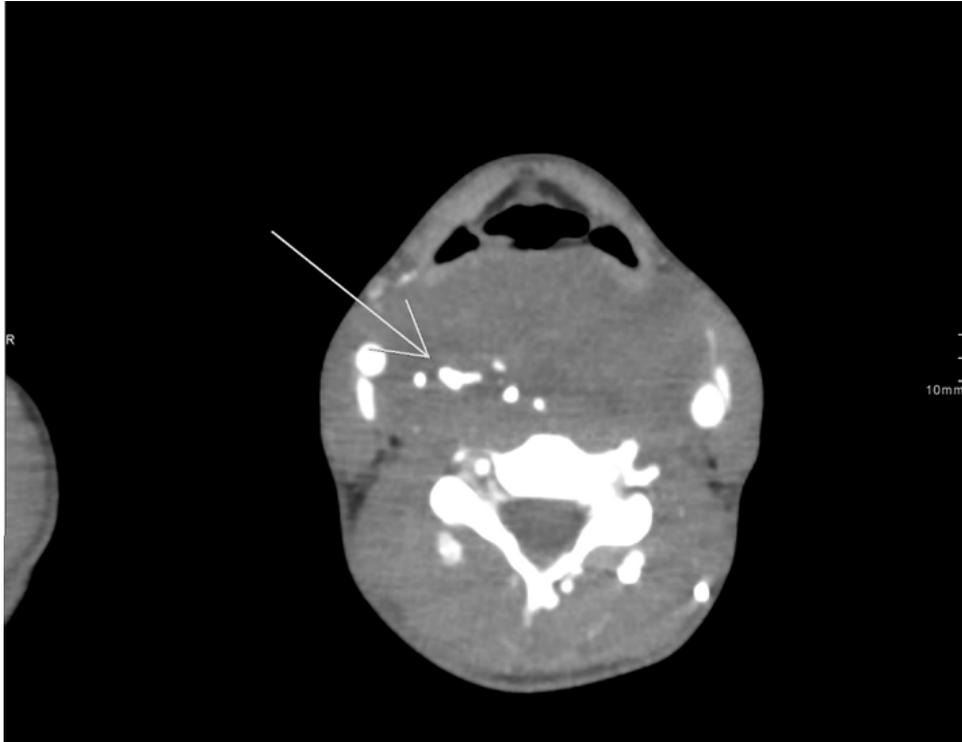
Axial CT scan of face and neck with intravenous contrast with evidence of tumor lesion of defined contours, heterogeneous with soft tissue density and calcifications inside, no enhancement after intravenous contrast.
